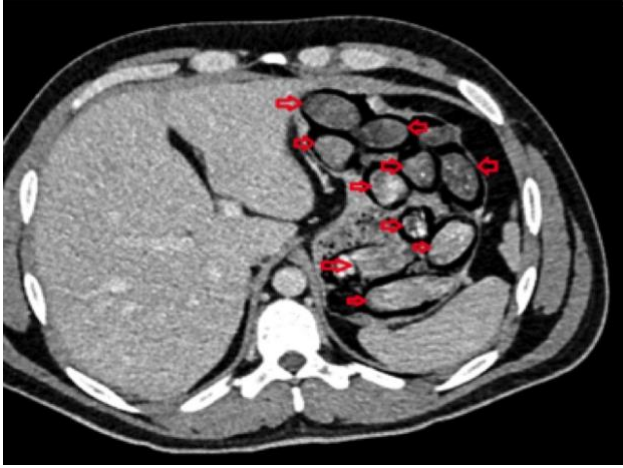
The abdominal CT shows multiple foreign bodies that may belong to smooth-contoured packages at the level of stomach, intestines and colon.
